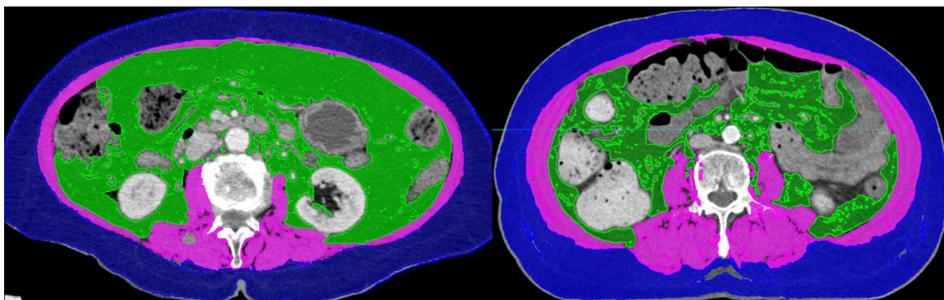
The computed tomography (CT) images of patients with sarcopenia (left) and without sarcopenia (right) who had similar body mass index.
